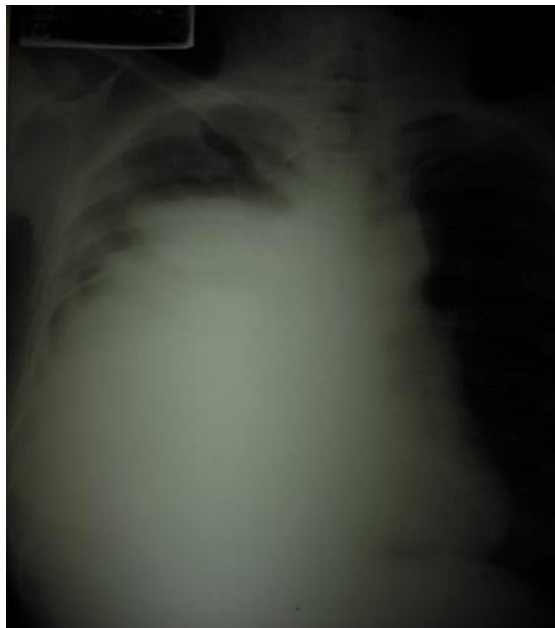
Repeat chest x-ray showing interval increase in mass size
